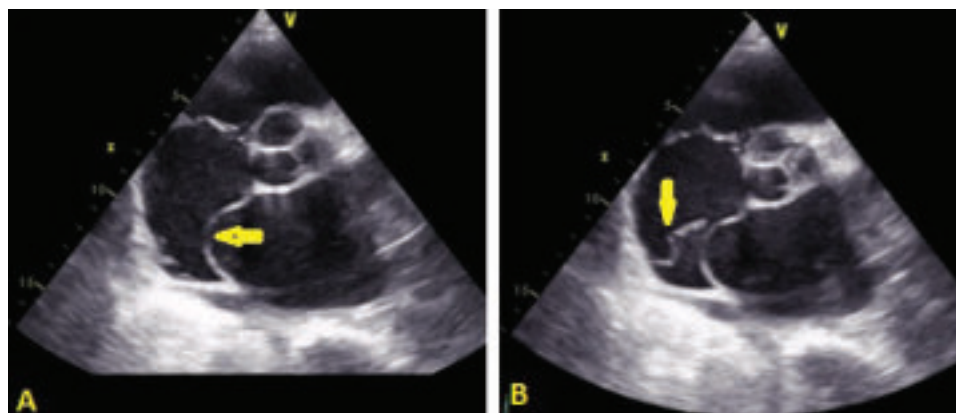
2D echocardiography, parasternal short axis view. Panel A showing atrial septal aneurysm marked by arrow; Panel B showing Chiari network in right atrium marked by yellow arrow.
